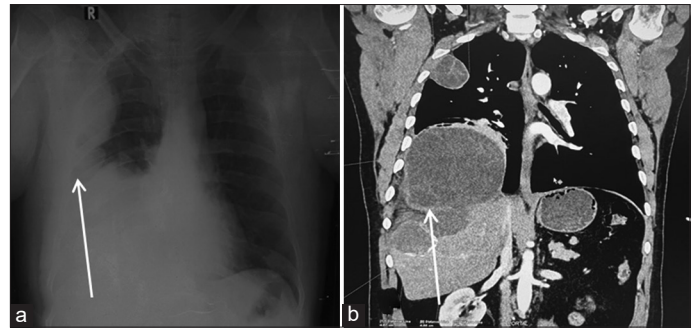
(a) Chest X-ray showing blunting of cardiophrenic and costophrenic angle with opacity in right lung; (b) computed tomography showing transdiaphragmatic herniation of hydatid cyst
